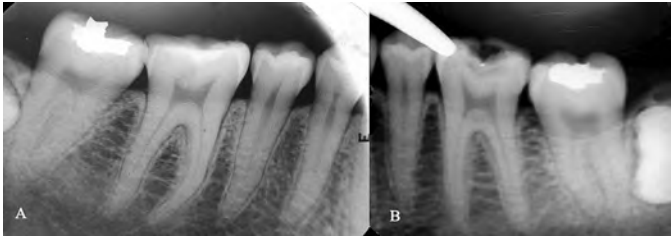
(Left) Radiograph showing the presence of a C-shaped root on the mandibular right second molar. (Right) Radiograph of the mandibular left second molar showing two separate roots. Case is 43 year old male.
